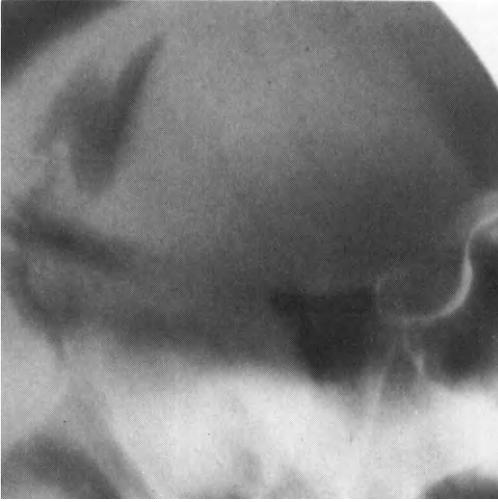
A filling film of an air encephalogram showing the gross displacement of the third ventricle and the lower edge of the mass in the interpeduncular cistern. (The CT scan of this tumour is shown in *Fig. 7.10a.*)
